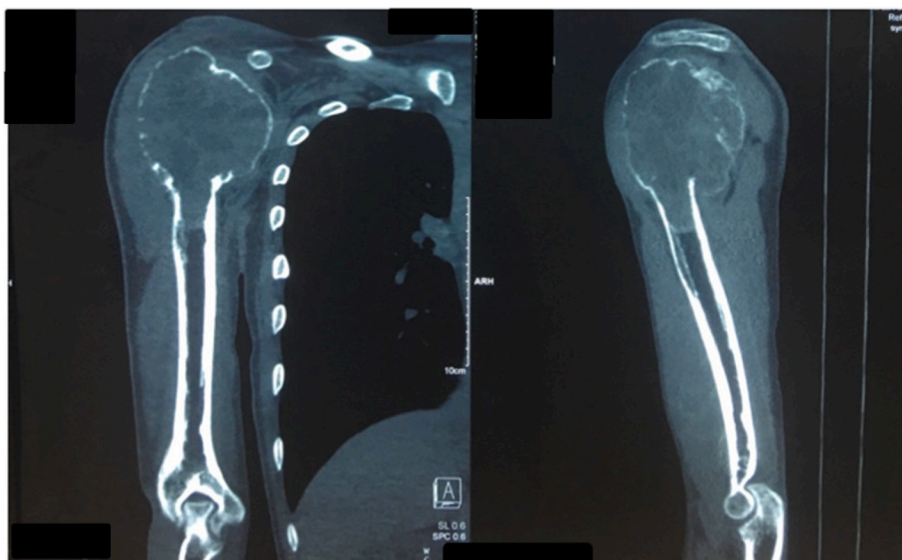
The CT scan provides an overview of the bone lesions, allowing us to accurately measure for the replacement joint.
